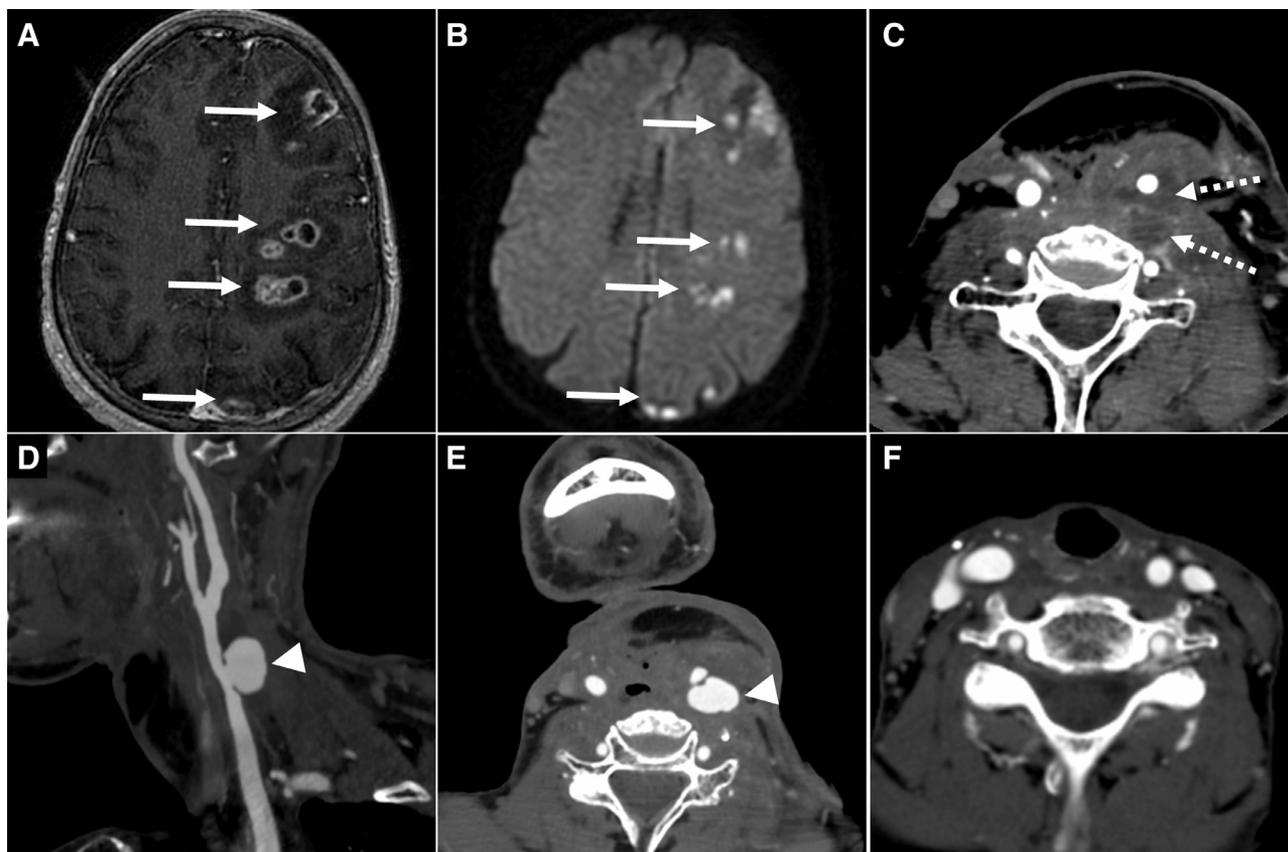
A 58-year-old with a history of advanced laryngeal cancer treated with chemoradiation and subsequent salvage laryngectomy, now presents with right body weakness. A brain MRI was performed including axial postcontrast (A) and diffusion weighted (B) sequences demonstrating multiple ring-enhancing lesions within the left hemisphere (A, arrows) with corresponding central diffusion restriction (B, arrows) concerning for septic emboli. A proximal vascular abnormality was suspected and a CTA of the head and neck was performed (C-E) which demonstrates a rim enhancing collection surrounding the left common carotid artery consistent with infection (C, dashed arrows). A focal vascular outpouching arising from the left common carotid artery (D-E, arrowheads) was noted centered within this region of infection consistent with an infected carotid pseudoaneurysm representing the proximal source for the intracranial thromboembolic disease. These findings were all new compared to the patient's baseline exam performed several years prior (F).
